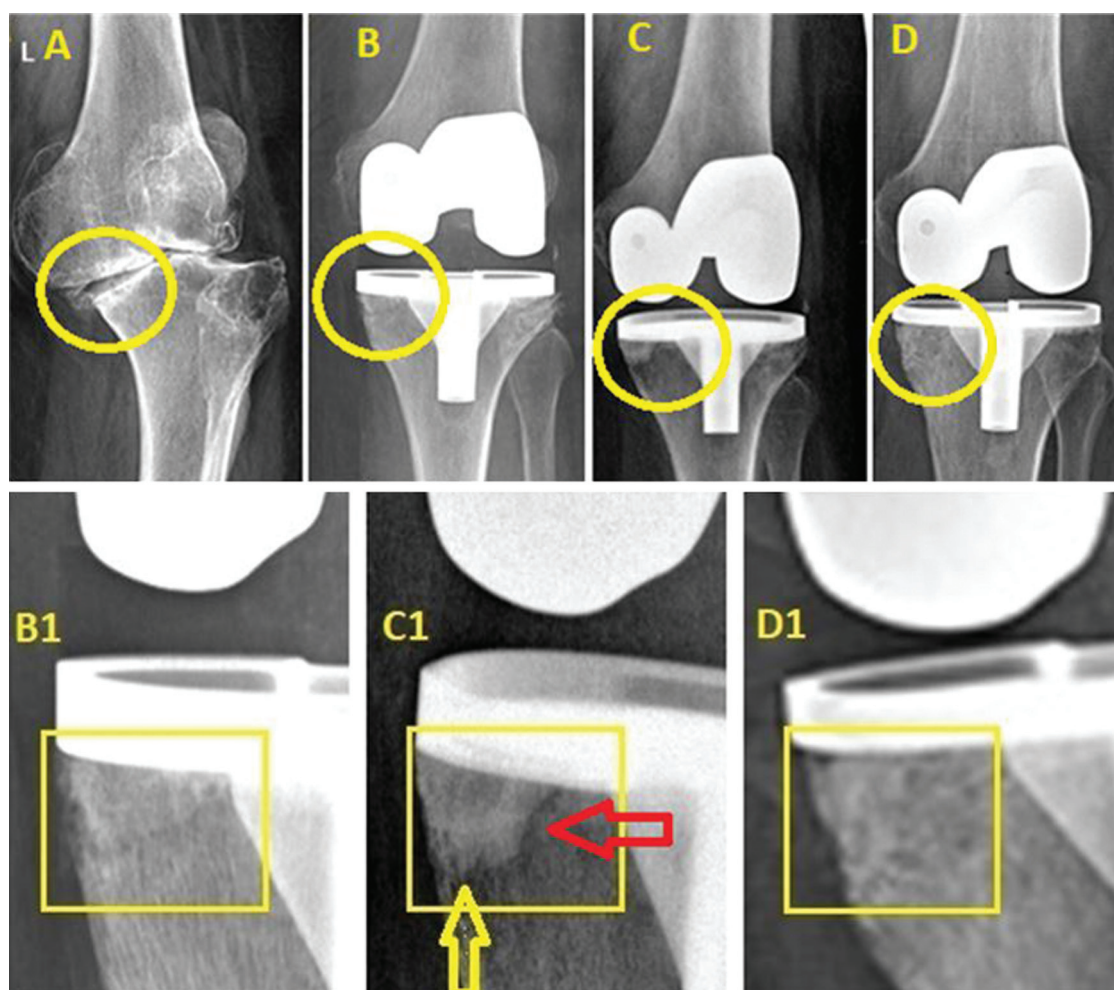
Scale 1:1.1: (A) preoperative radiograph showing a bone defect of the medial tibial condyle; (B) control radiograph prior to discharge of the patient from the hospital (5-6 days after the surgery); (C) radiograph 7 months after surgery; (D) radiograph 24 months after surgery. Scale 1:4: (B1) no graft migration observed due to tight fixation at the area formed. The contact border seen between the graft and the bone; (C1) partial sclerosis of the graft and bridge-like trabeculation formed in the distal direction (yellow arrow). Partial resorption observed at the identifiable graft-to-bone interface (red arrow); (D1) the graft completely reconstructed in the bone with no border seen between the graft and the bone
